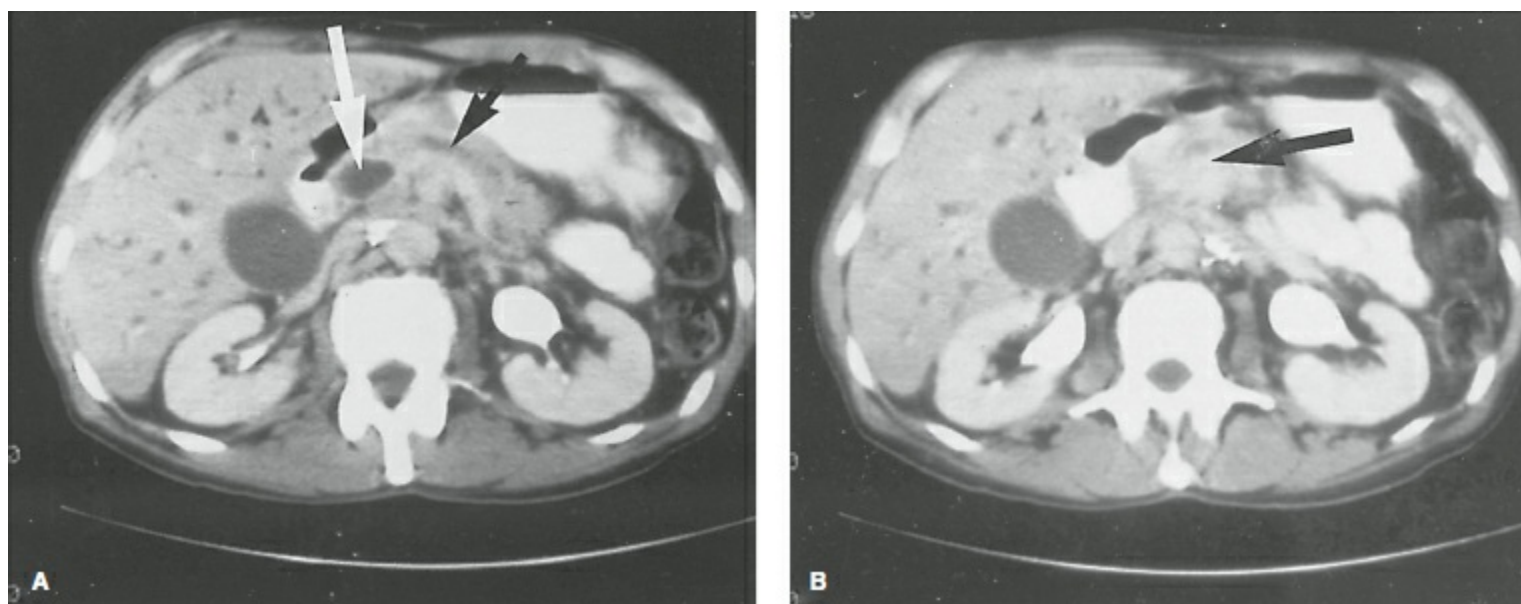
Computed tomogram of the abdomen of a patient with adenocarcinoma of the pancreas. A: The obstructed and dilated common bile duct (*light arrow*) and pancreatic duct (*dark arrow*) can be seen. In the adjacent cross section B, a large mass is present in the head of the pancreas (*arrow*).
